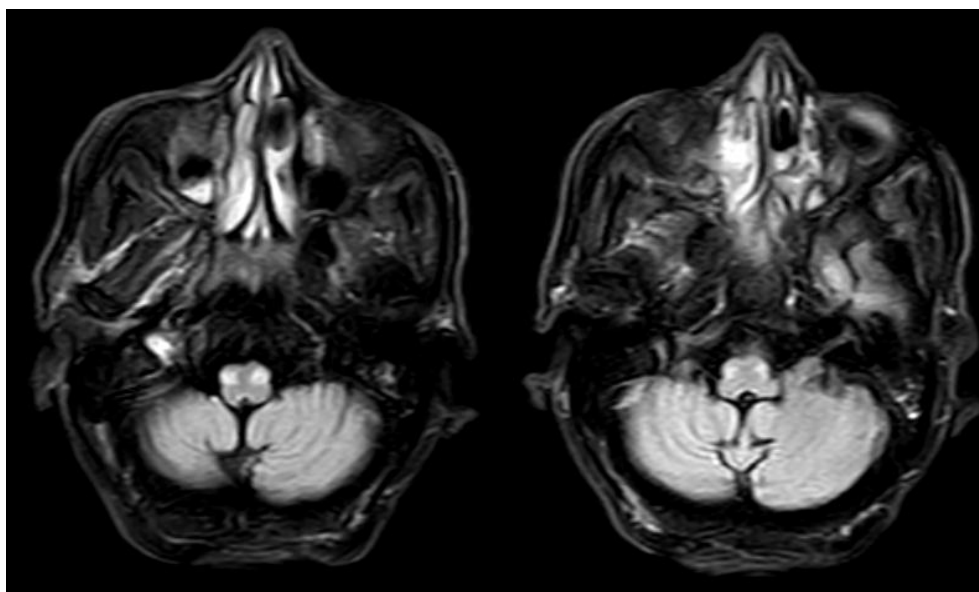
MRI flair images.
